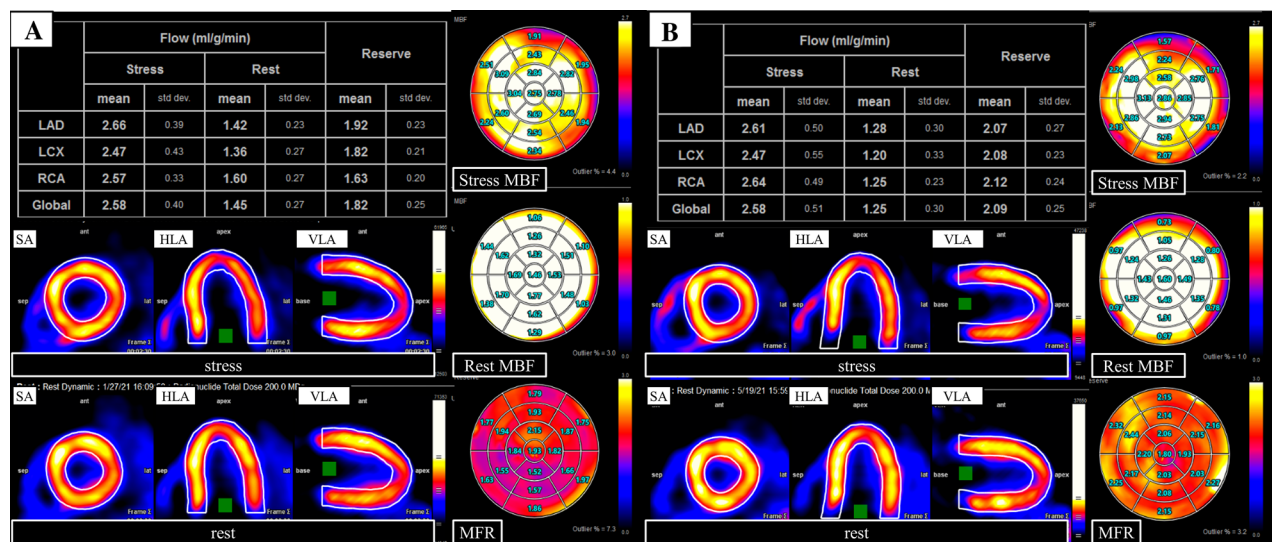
Comparison of the initial (A) and repeat (B, after 3 months of corticosteroid therapy) ATP-induced stress and rest ^{13}N -ammonia PET/CT. The initial global myocardial blood flow (MBF) at stress and rest were 2.58 and 1.45 $\text{mL}\cdot\text{min}^{-1}\cdot\text{g}^{-1}$, respectively; the initial and follow-up myocardial flow reserve (MFR) were 1.82 (rate–pressure product [RPP]-corrected MFR, 1.56) (A, left) and 2.09 (RPP-corrected MFR, 1.45), respectively, with the stress MBF unchanged at 2.58 $\text{mL}\cdot\text{min}^{-1}\cdot\text{g}^{-1}$ (B, left). These findings were similar in the 17-segment between the initial and follow-up PET examinations (A, right and B, right). Myocardial perfusion imaging in the short axis (SA), vertical long axis (VLA), and horizontal long axis (HLA) showed no significant reduction in tracer uptake during stress and rest phases in both studies (A, bottom and B, bottom).
